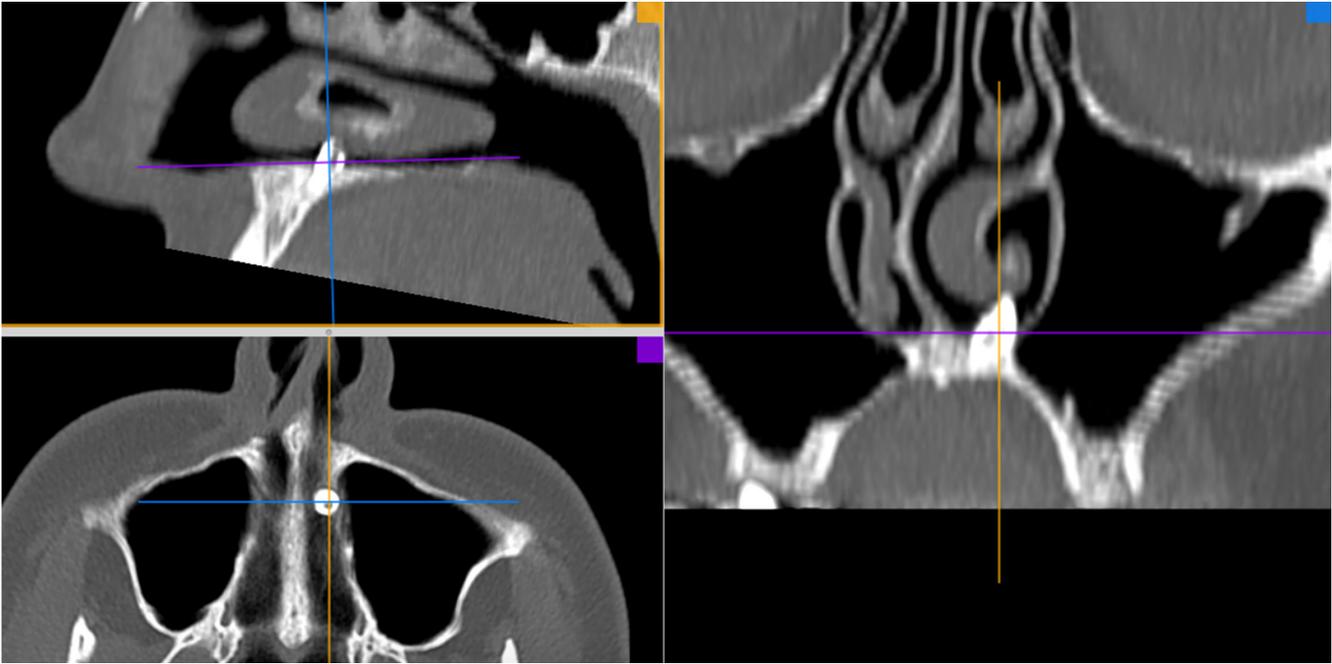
Computed tomography imaging. Three projections show an ectopic tooth evident in the hard palate, which punctures into the left nasal cavity.
